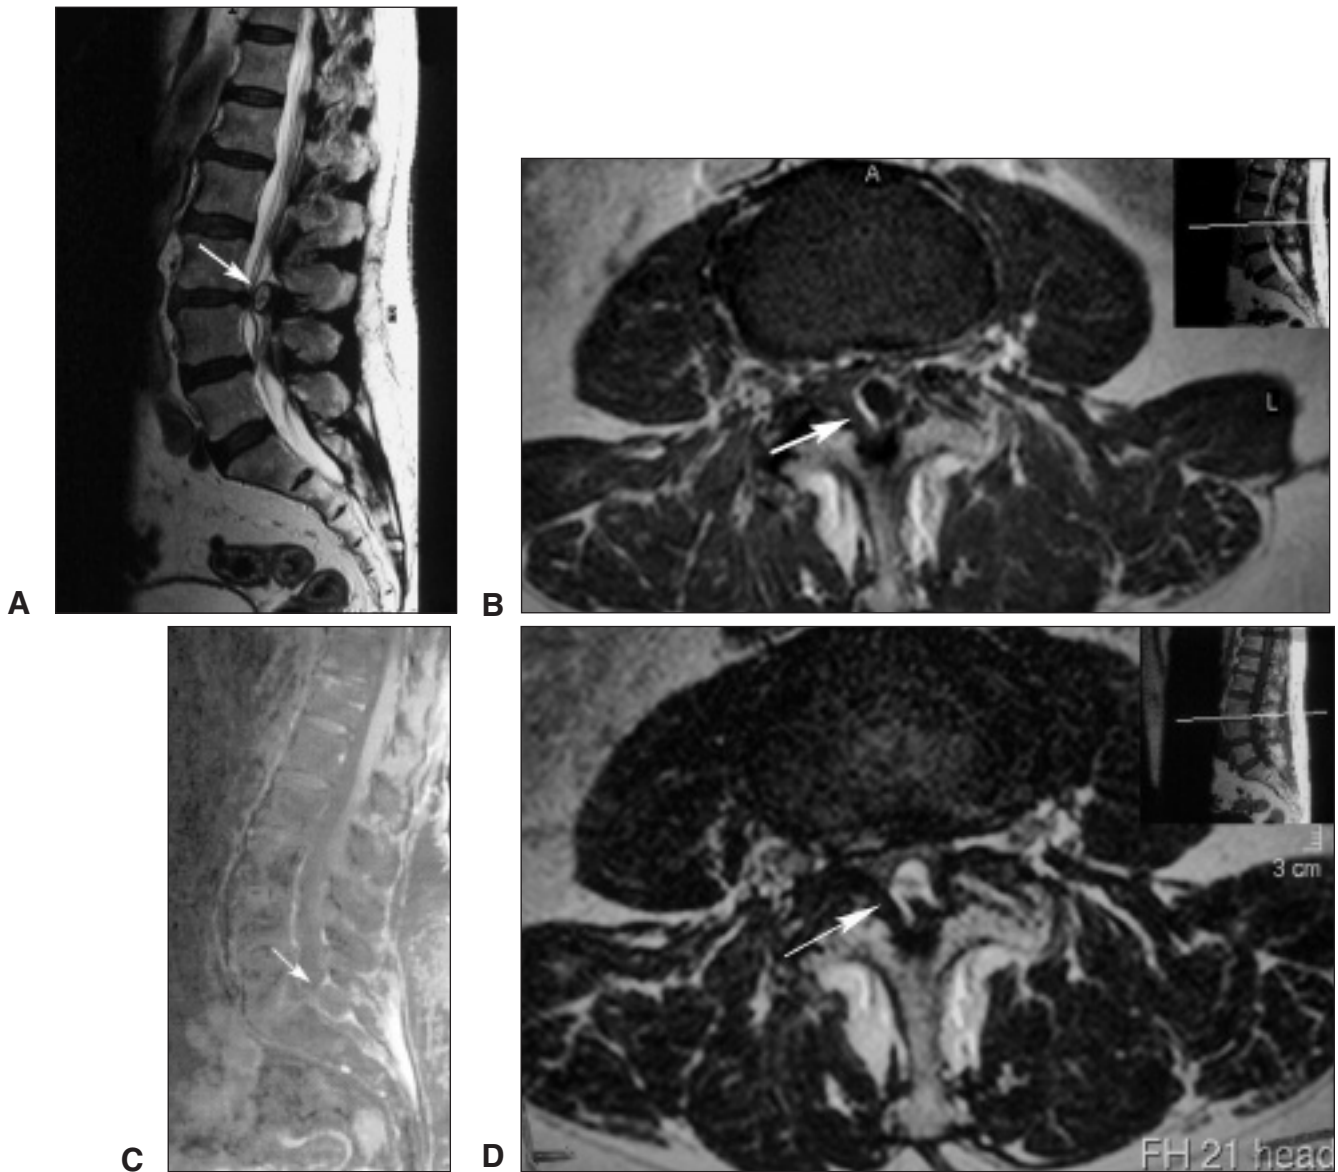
Magnetic resonance imaging appearance of ligamentum flavum cysts from our case series. T2 sagittal (A), T1 axial (B), T1 with gadolinium in sagittal section (C), and T2 axial (D).
